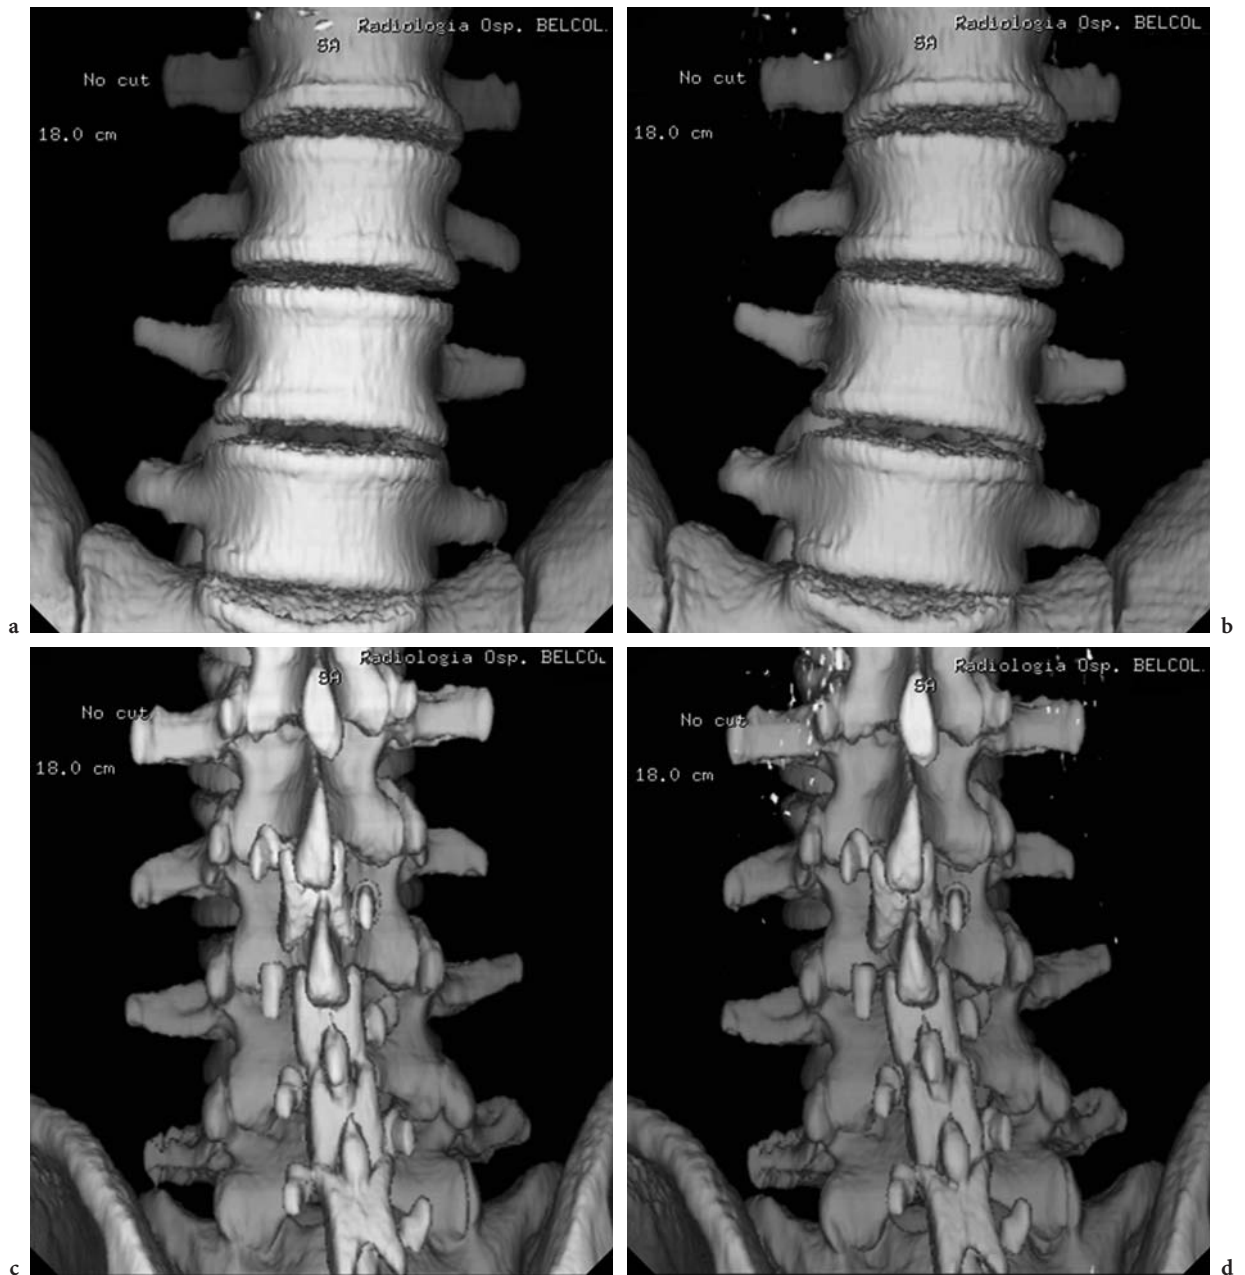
a Same Patient as in Fig. 9.16. Basal CT, 3D posterior view. In L4–L5 a DIAM has been positioned. The spine has right sagittal assessment; partial recovery of correct articular and spinous processes spatial situation. The patient reports only partial reduction of her symptoms in orthostatism. b Same patient; AL-CT, 3D posterior view. The spine still has right sagittal assessment; superior translation of L5–S1 posterior arch (paradoxical motion) is still present. The orthostatic low back pain appeared during axial loading
